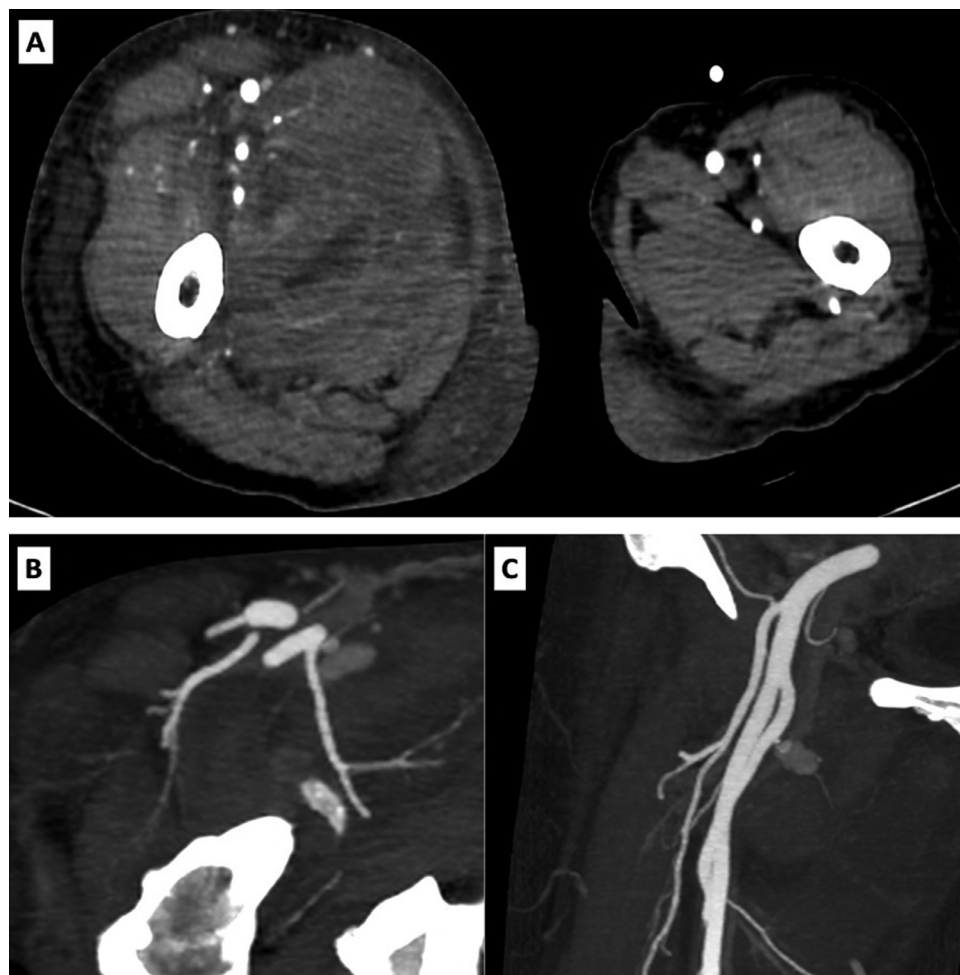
Computed tomography angiography of the lower extremities: Axial plan (A) showed a large hematoma of the right thigh with edema of surrounding soft tissue. MIP axial plan (B) and coronal plan (C) showed a pseudoaneurysm arising from the right deep femoral artery.
